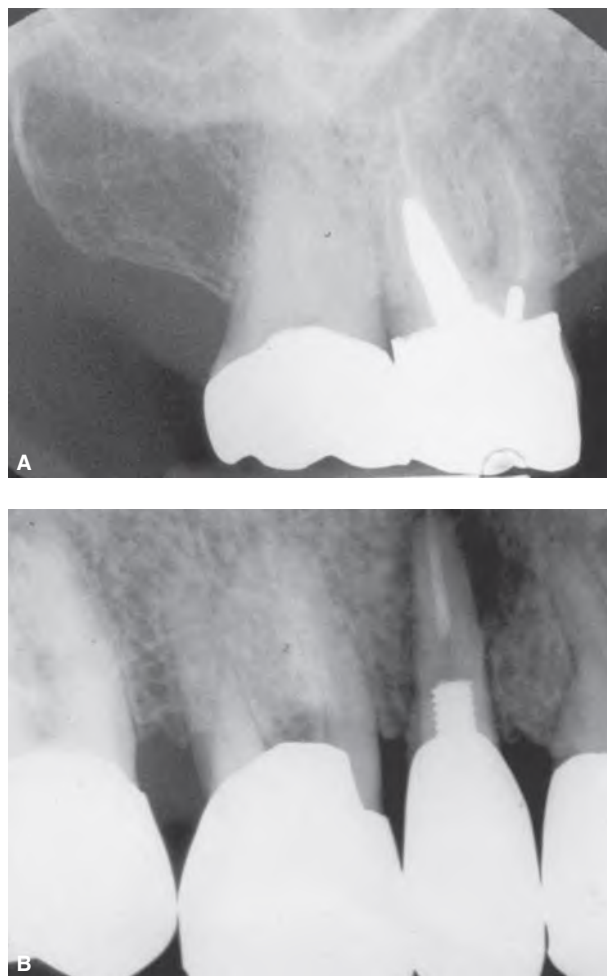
Excessive post diameters. A. Large-diameter post placed in the palatal root of the maxillary molar. B. Large-diameter threaded post caused fracture of the maxillary second premolar. The radiographic appearance of the bone is typical of a fractured root—a teardrop-shaped lesion with diffuse border.
